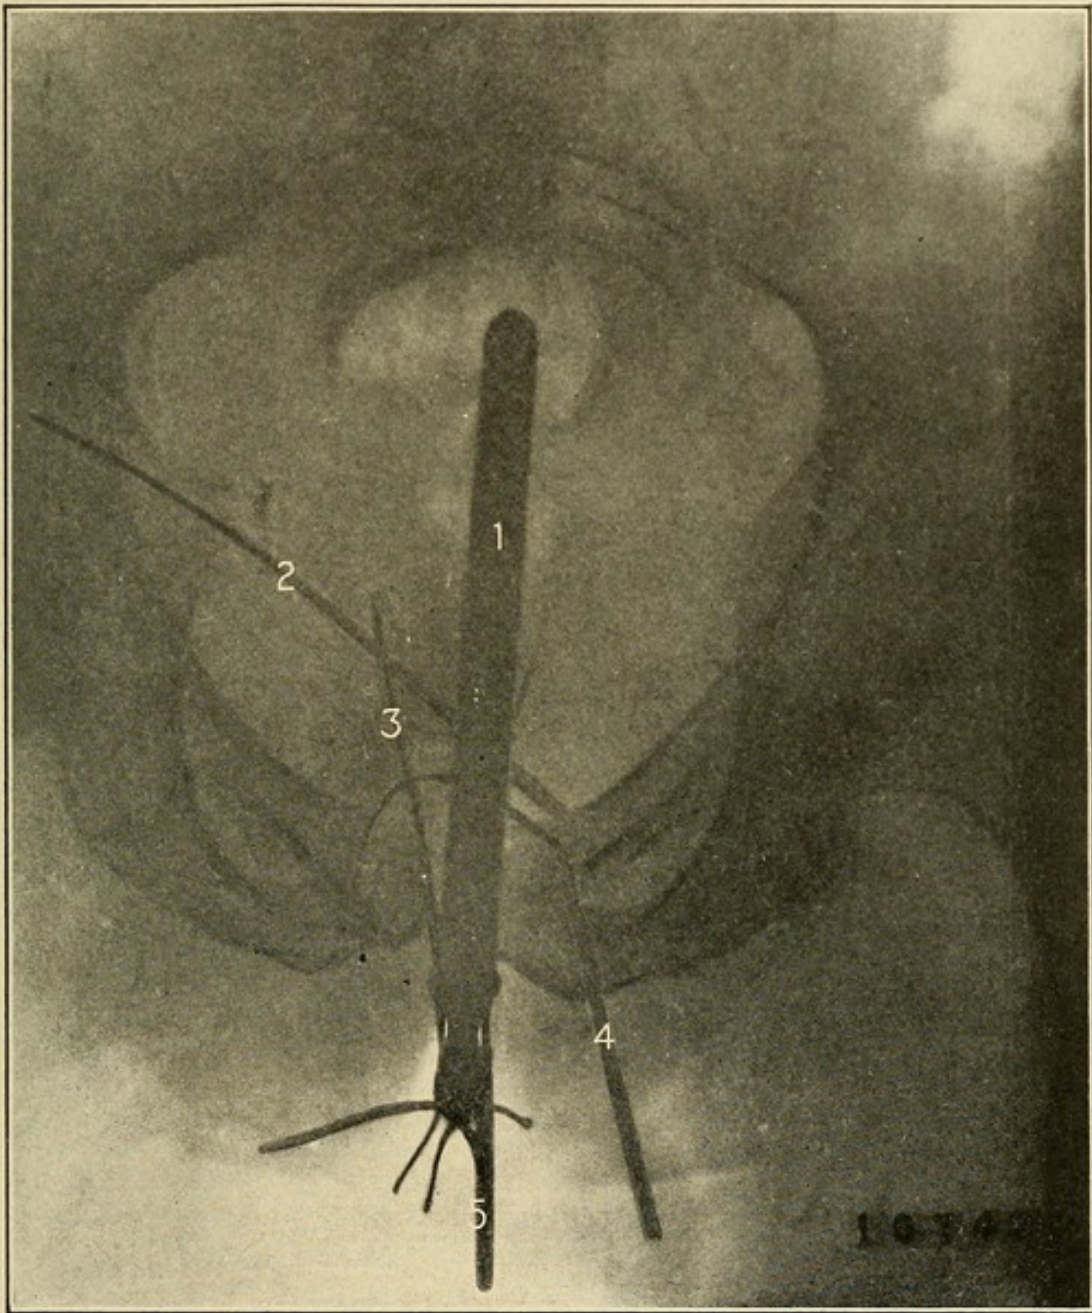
Radiograph (rear view) showing speculum in rectum and probes in numerous mucous channels in peri-rectal spaces. (Dr. A. B. Jamison.)
